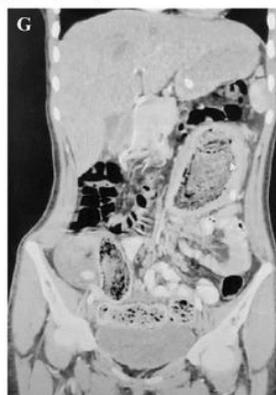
(G): CT findings; case 3
